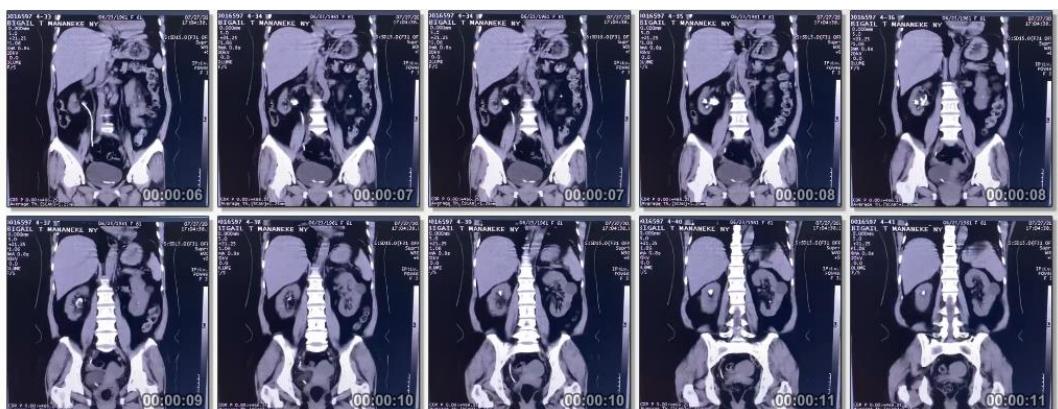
CT-scan coronal view
